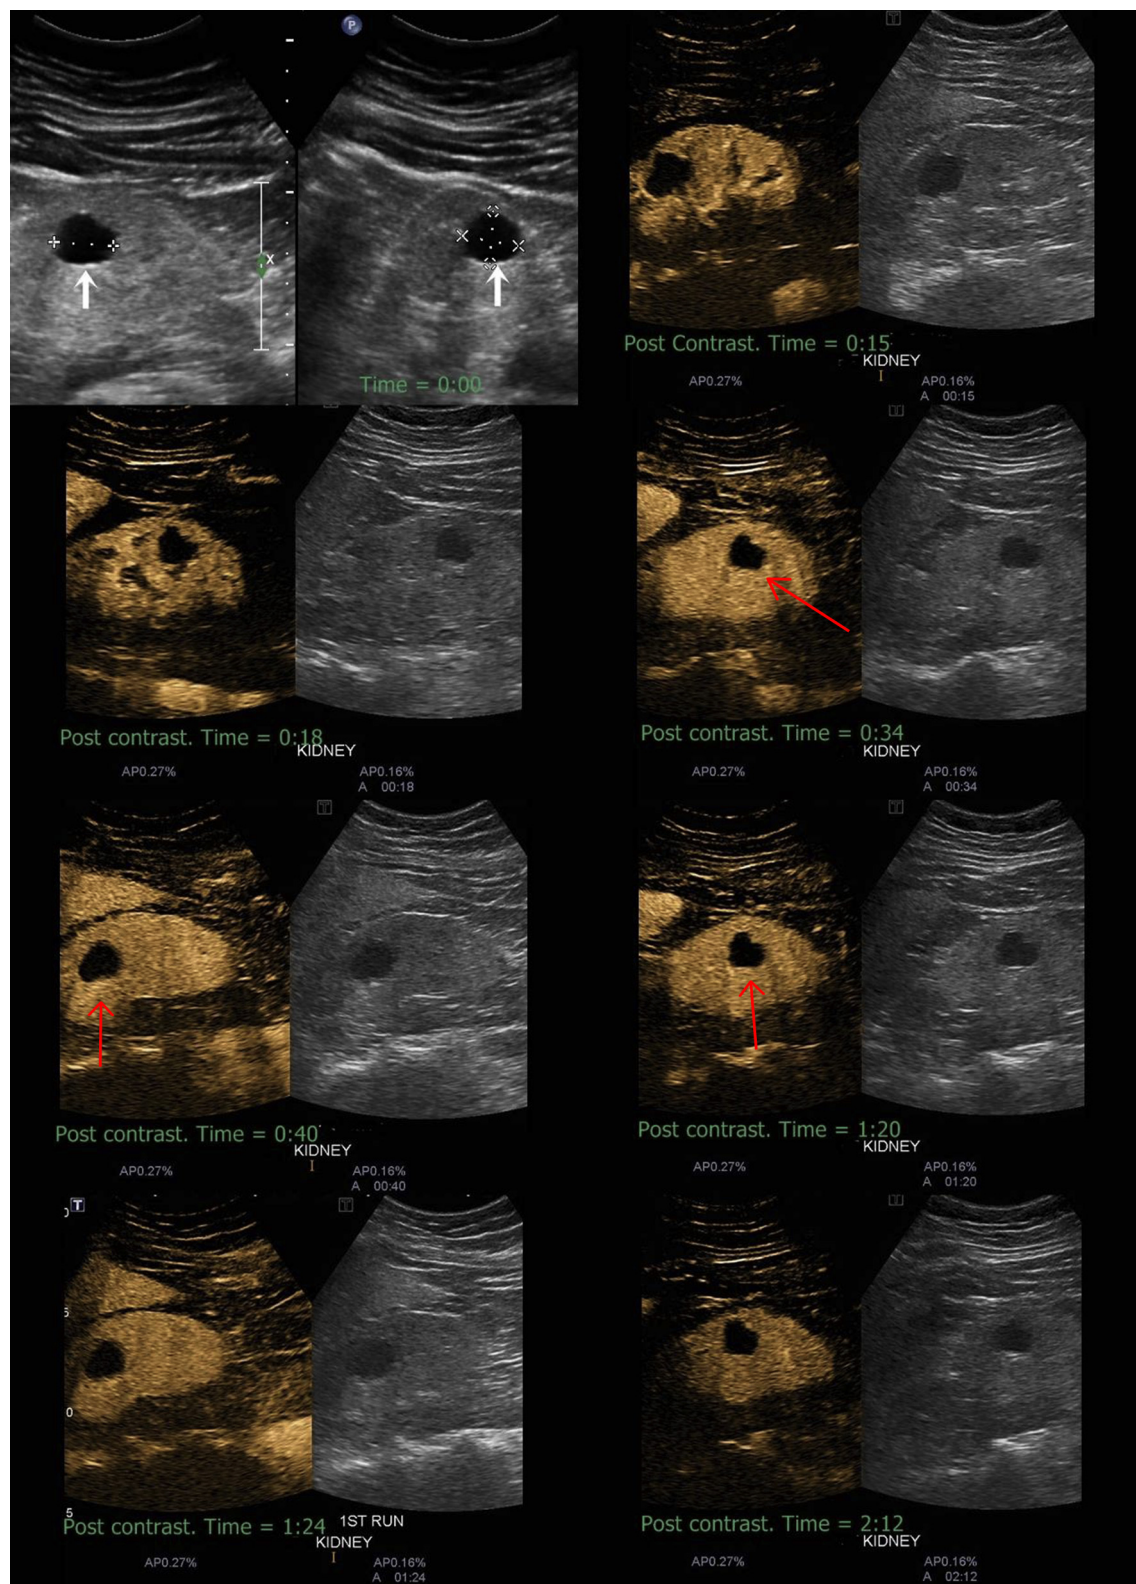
Simple renal cyst. Contrast-enhanced ultrasound shows cyst with anechoic cyst without septa, calcification, or solid components. No enhancement is noted after intravenous contrast agent injection. It is characteristic for a simple Bosniak Type 1 cyst and does not entail further investigation.
